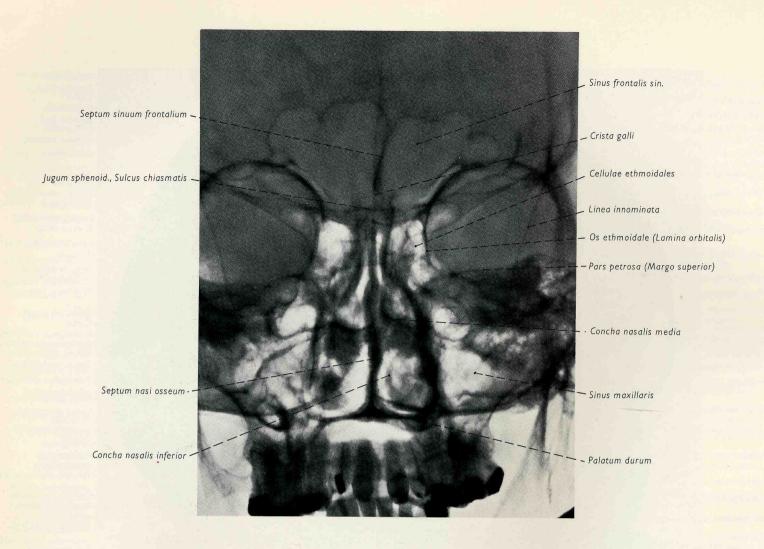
Posteroanterior roentgenogram of paranasal sinuses I (L. Wicke, Vienna).
